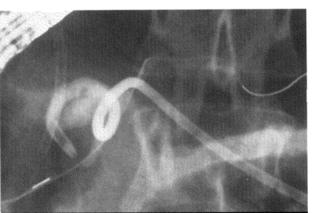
A, Percutaneous drain placed in fluid collection (arrow) 3 weeks after islet cell enucleation from pancreatic tail. Pancreatogram was obtained at the time of drain placement. B, Abdominal CT demonstrates drain (arrow), with resolution of fluid collection 2 weeks after drainage. The patient had persistent hyperamylasemia with fistula flow approximating 250 ml/day. C, Endoscopically placed prosthesis (arrow) resulted in fistula closure within 48 hours.
